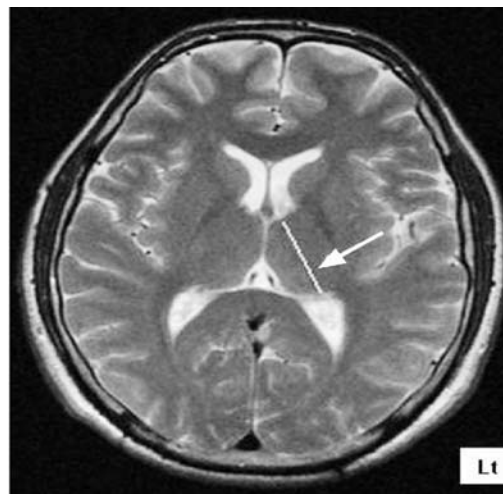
Measurement of the anteroposterior length (arrow) of left thalamus in MR imaging.
